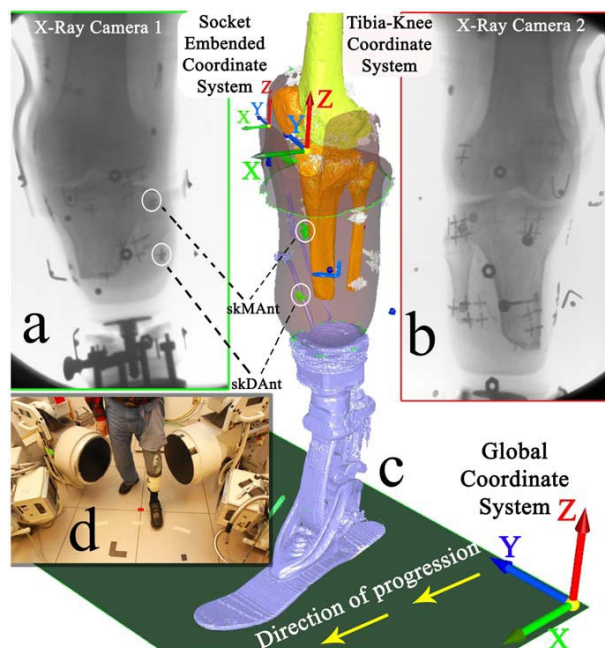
Measuring pistoning using Roentgen Stereogrammetric Analysis (Papaioannou *et al.*, 2010).
